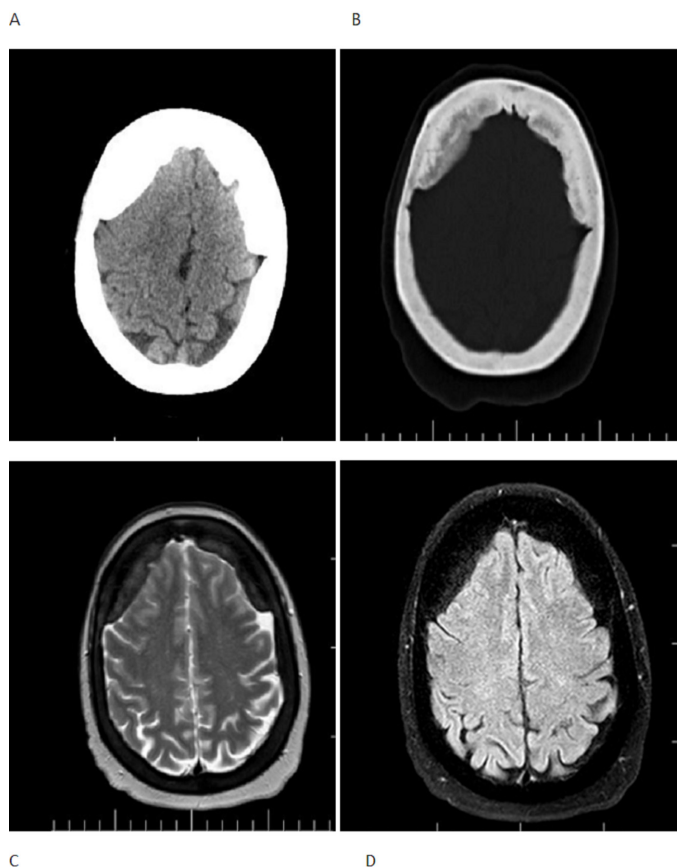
Computed tomography (A and B) and Magnetic resonance image (C and D) done in showing bilateral calcified/ossified chronic subdural haematoma
